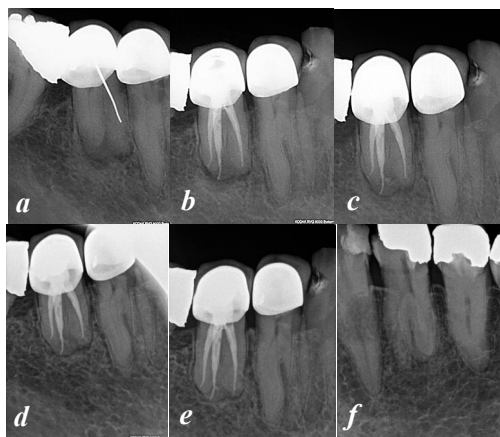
First case of retreatment of #45: (a) preoperative, (b) final, (c) 6 months control, (d) 16 months control, (e) 27 months control and (f) controlateral radiographs. Healing of the periapical lesion after the endodontic retreatment of the tooth. The controlateral second premolar appears the anatomic abnormality, also
